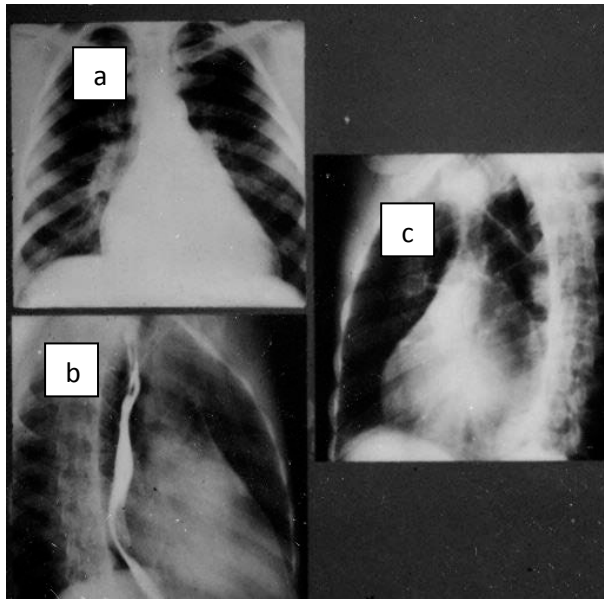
Heart radiographs in a direct (a), right (first) oblique projection (b), left (second) oblique projection (c); a) the mitral configuration of the heart. On the left contour lengthening of the left ventriculus arches, ear of the left atrium, pulmonary artery is detected. On the right contour the arch of the right auricle is increased); b) in the right (first) oblique projection on the arch of small radius (<6 sm) the contrasted oesophagus is displaced due to the increased left auricle, increases the left ventriculus arch); c) in the left (second) oblique projection on a forward contour the arch the bottom arch right ventriculus is increased. On a back contour arches of the left auricle and left ventriculus are extended.
